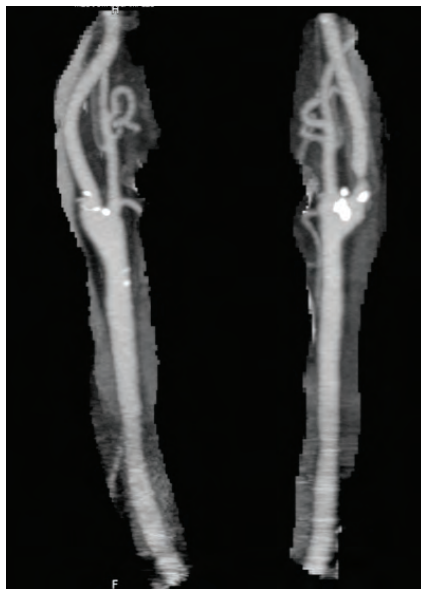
CT ANGIO 3D reconstruction: Left Internal Carotid Artery stenosis.
